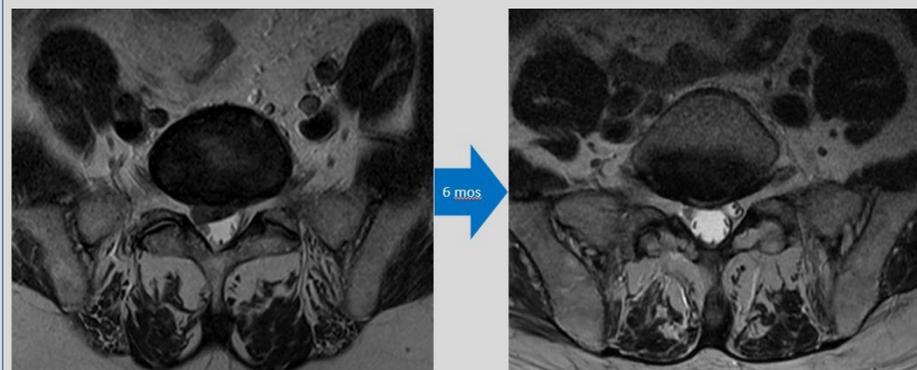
Axial T2-weighted MRI demonstrating initial L5-S1 disc extrusion at presentation followed by resolution.
